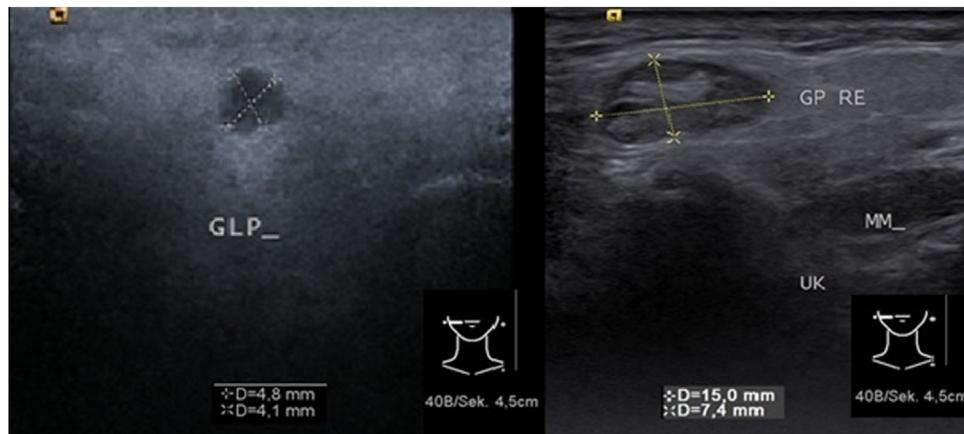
Left: Sonographic picture of a lesion in the right parotid gland 12 months after surgery and verification of a cystadenolymphoma on the same side. Right: The same lesion, 55 months later, with a significant increase in growth and intralesional septations (GLP: parotid gland, MM: master muscle, UK: mandible).
